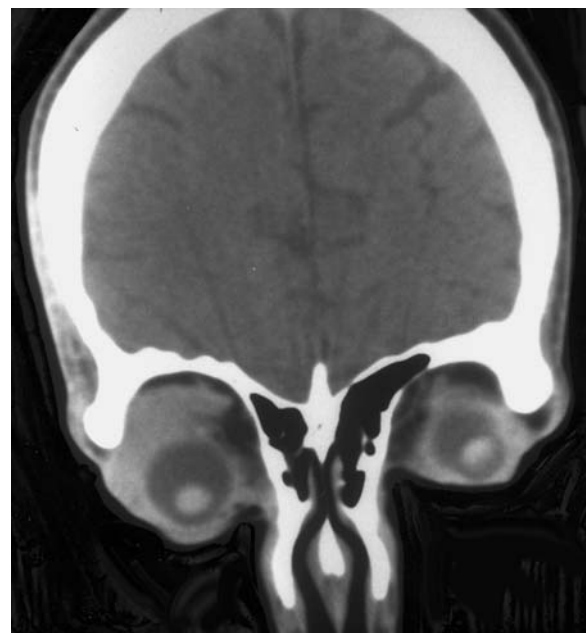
A 45-year-old man with progressive, extra-axial right eye protrusion. Diagnosis: lymphoma. CT: a Axial view of the upper orbit with homogeneous tumor-like enlargement of the right lacrimal gland, expanding over the entire lateral and superior globe, apparently depressing the globe. b Coronal view demonstrating shifting of the globe, although differentiation of the formation from normal lacrimal structures is not possible
